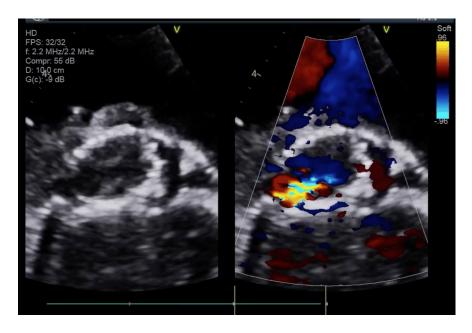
Transthoracic Echocardiogram in parasternal short axis view post TAVI, demonstrating a moderate jet of valvular regurgitation.
